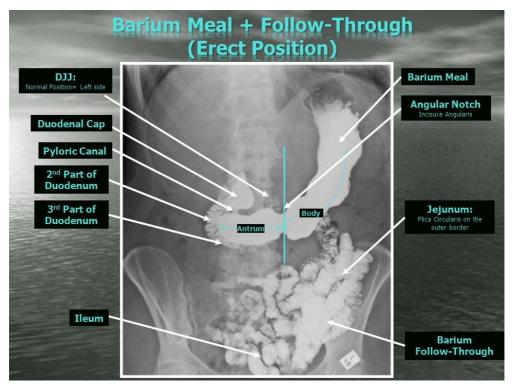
Contrast radiograph of stomach—barium follow through l, anteroposterior view.
